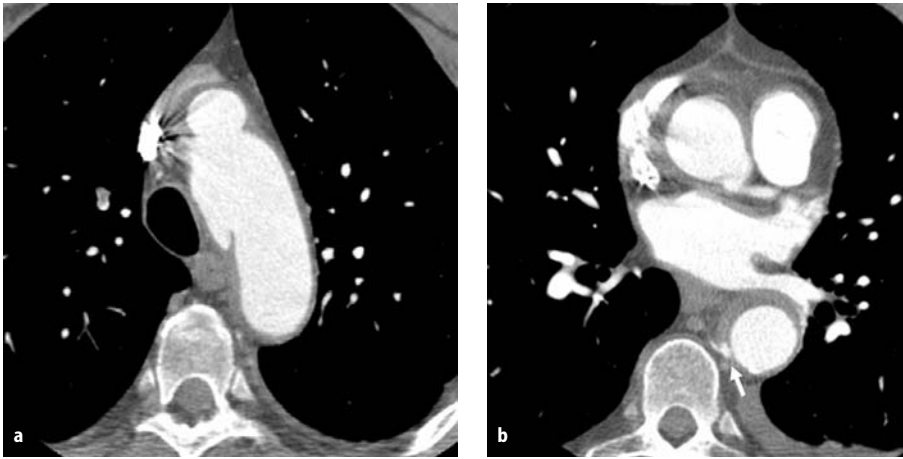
An 80-year-old man presented with back pain. Chest CT showed a penetrating ulcer in the aortic arch (a) with gaping communication between the ulcer cavity and the aortic
